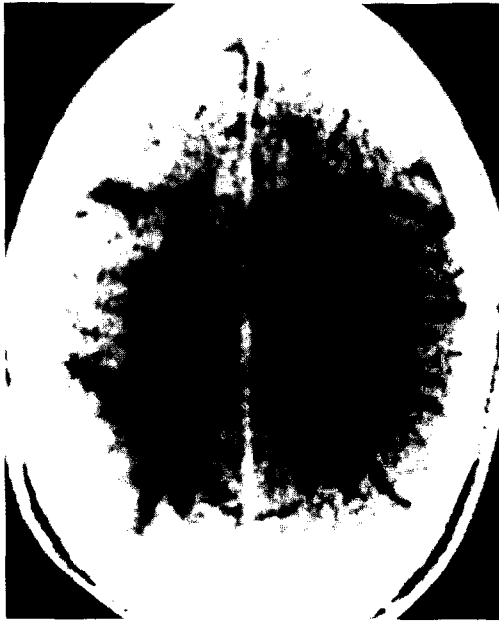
Axial brain CT shows bilateral radiolucencies in the parieto-occipital regions believed to be watershed infarctions. Patient manifested simultanagnosia.
